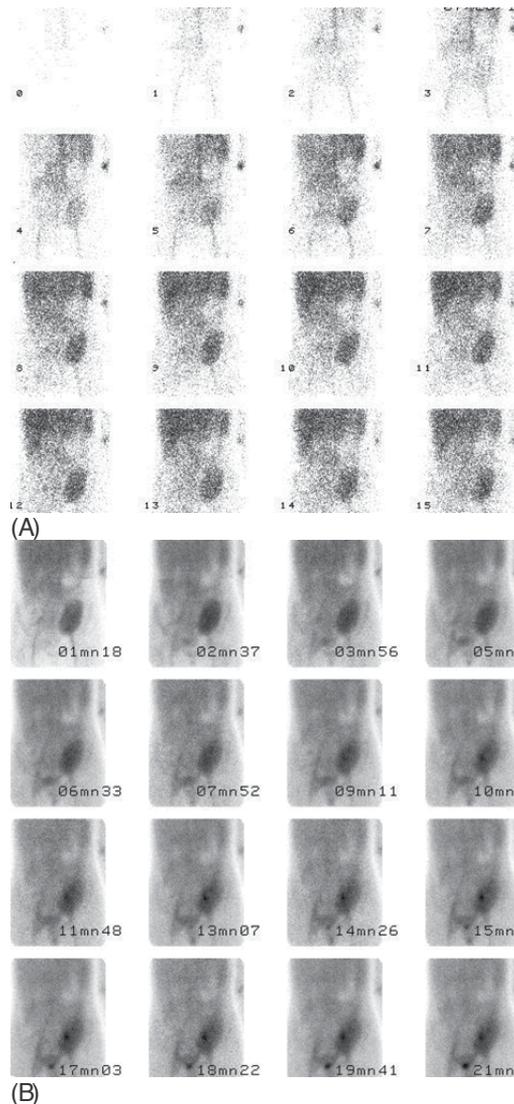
(A) and (B): 99mTc-DTPA renal scintigraphy. Two week follow up. Depressed arterial blood flow of a discrete degree and glomerular function deficit of moderate degree
